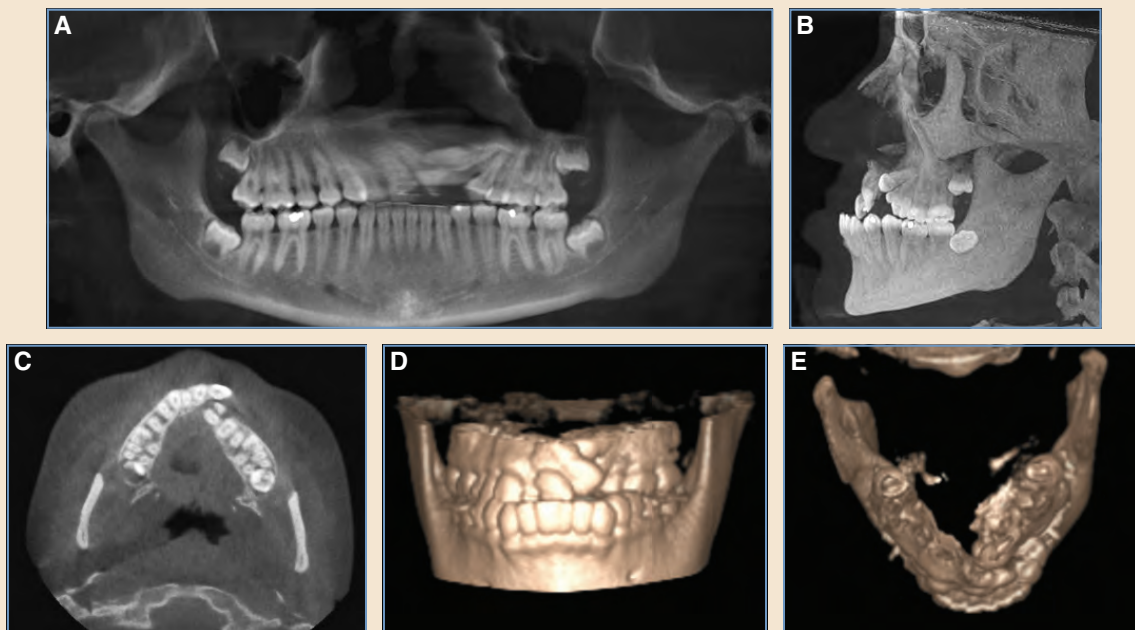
CBCT scans of a 15-year-old female with a history of left cleft lip and palate. The scans were obtained for a preoperative workup before palatal expansion and alveolar bone grafting. The variety of image formats demonstrates the versatility and utility of CBCT. A, A traditional Panorex image generated from the CBCT scanner. B, A lateral cephalogram generated from the CBCT scanner, highlighting the patient's midface hypoplasia and negative overjet. C, An axial CBCT cut demonstrates well the patient's left-sided palatal collapse and alveolar bone deficit. The patient will require palatal expansion to reestablish the proper position of the maxillary arch, followed by alveolar bone grafting of the bony defect to prepare for an osteointegrated dental implant. D and E, An AP and worm's-eye view of 3D reconstructions generated using CBCT data.
